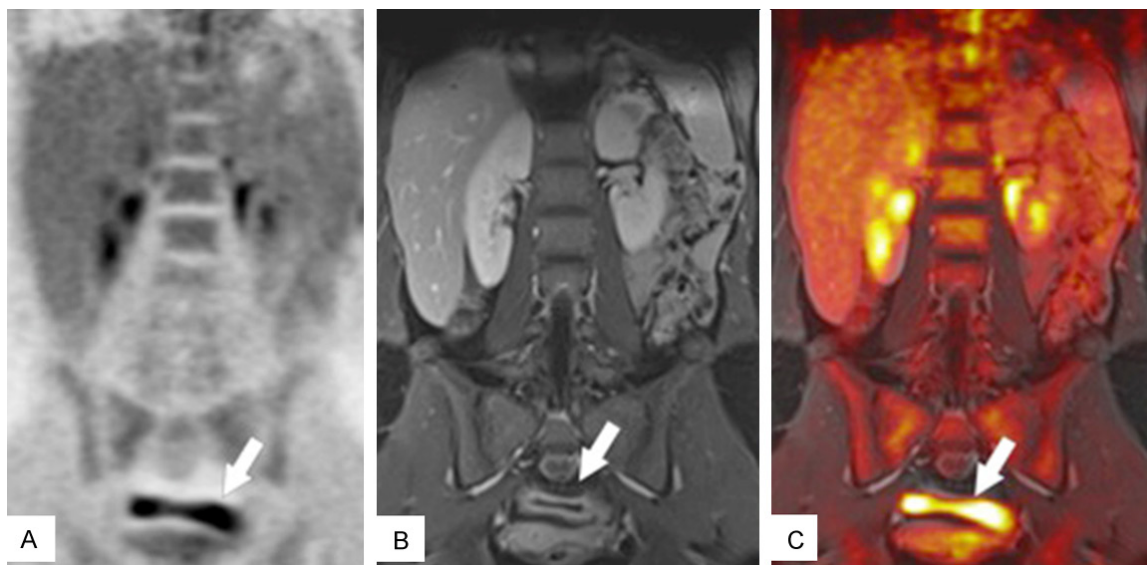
Concordance of PET and MR in correctly identifying active inflammation. Coronal PET (A), coronal CE-VIBE (B), fused PET/MR (C). An actively inflamed bowel loop (arrow) demonstrates wall thickening, pronounced enhancement, and marked FDG uptake (arrow).
